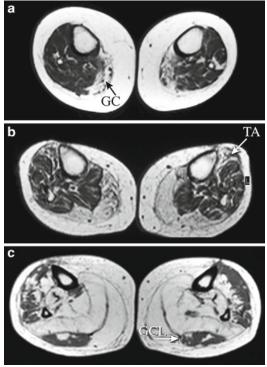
Axial T1-weighted MRI scans of the lower legs of patients with inclusion body myositis. (a) Isolated fatty infiltration of the gastrocnemius muscles (GC). (b) More pronounced fatty infiltration of the gastrocnemius muscles and anterior tibial muscles (TA). (c) Severe, relatively symmetrical fatty infiltration of almost all posterior compartment muscles, with relative sparing of the lateral head of the gastrocnemius muscle (GCL). The anterolateral compartment is affected to a lesser degree
